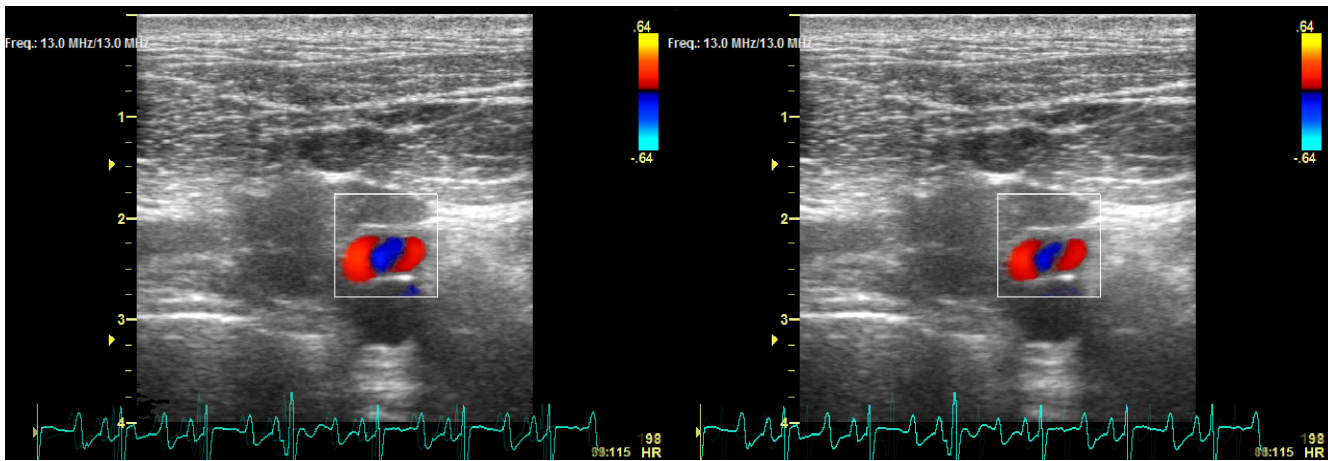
Dean vortices at cross-sections obtained transcatheterly by color Doppler ultrasound. Color demonstrates the direction of velocity components parallel to the view plane. Red color exhibits flow towards, whereas blue flow away from the probe. Maximum (left) and minimum inlet flow rate (right).
